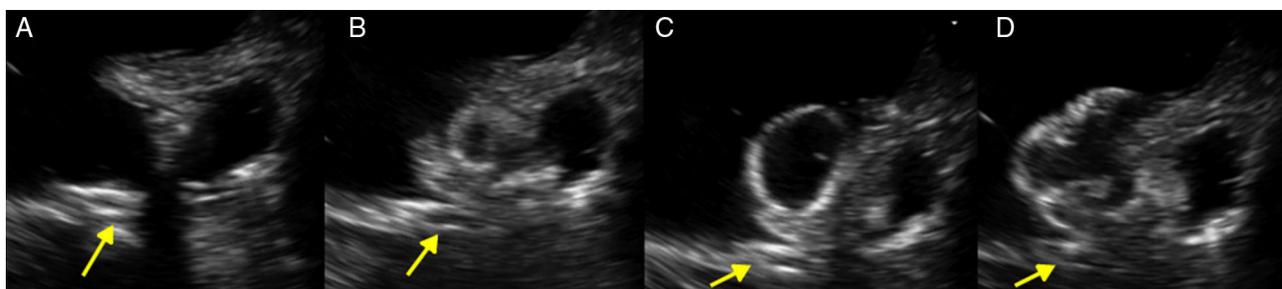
Intraoperative monitoring of deployment of the Amplatzer device by transesophageal echocardiography (A–D). Stents previously placed in the circumflex artery (yellow arrows) can be seen in the vicinity of the left atrial appendage, immediately next to the device landing zone.
